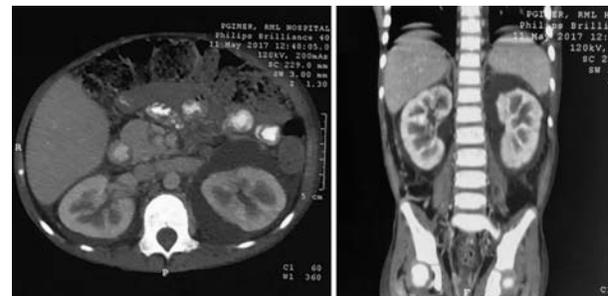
Contrast CT (CECT) abdominal scan showing bilateral perirenal fluid (white arrows) with scalloping of left kidney (white arrow head), thickened bilateral lateroconal fascia with pararenal fat stranding.
